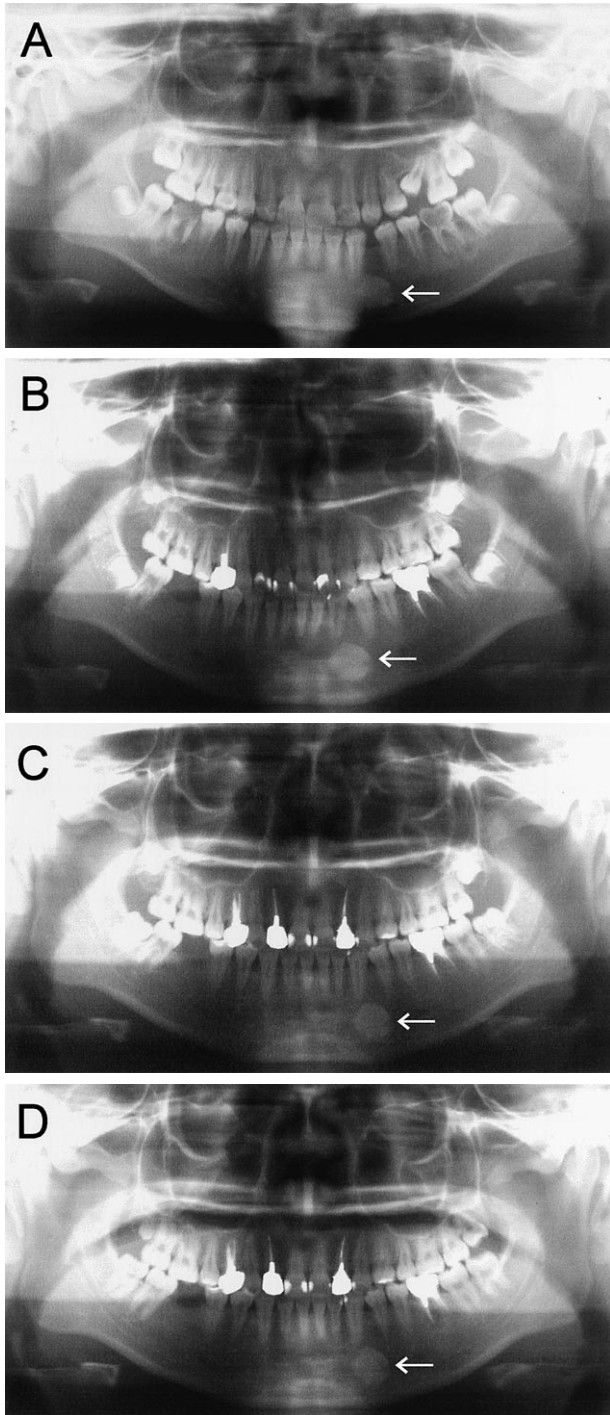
Orthopantomographs taken at 10Y1M (A), 12Y9M (B), 15Y2M (C), and 18Y3M (D)
